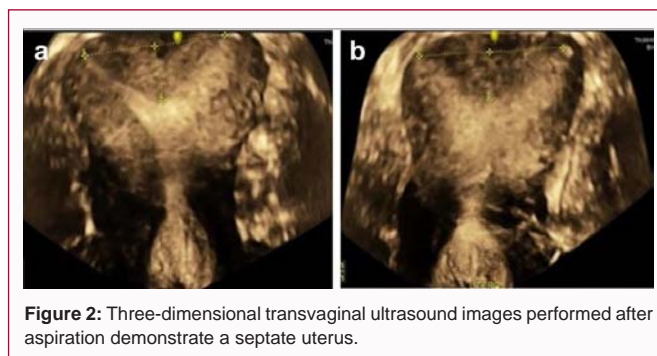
Three-dimensional transvaginal ultrasound images performed after aspiration demonstrate a septate uterus.
